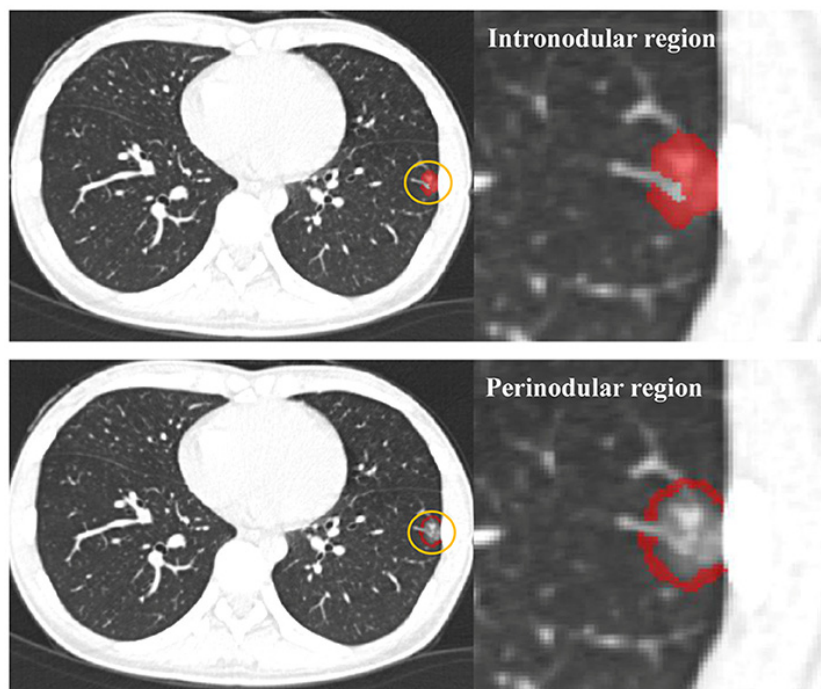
CT images of lung cancer lobulation and microvascular invasion
